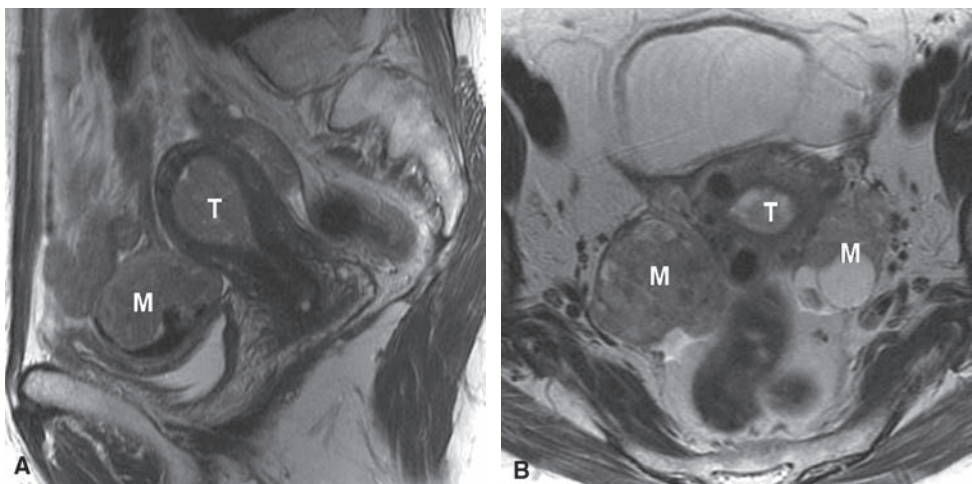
Stage IIIA endometrial carcinoma. Sagittal T2W FSE MR image (A) shows a tumor deposit on the serosa of the sigmoid colon (M in A) from a grade 3 endometrioid endometrial carcinoma (T in A). Axial T2W FSE MR image (B) in a different patient shows a clear cell endometrial carcinoma (T in B) with metastases to both ovaries (M in B).
